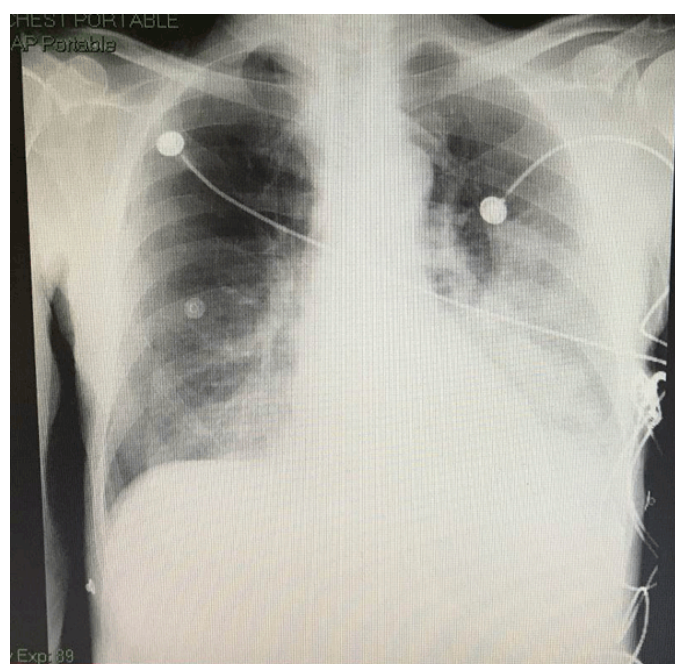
Chest X-ray showing perihilar thickening, left costophrenic angle effacement and left lower lobe consolidation.
